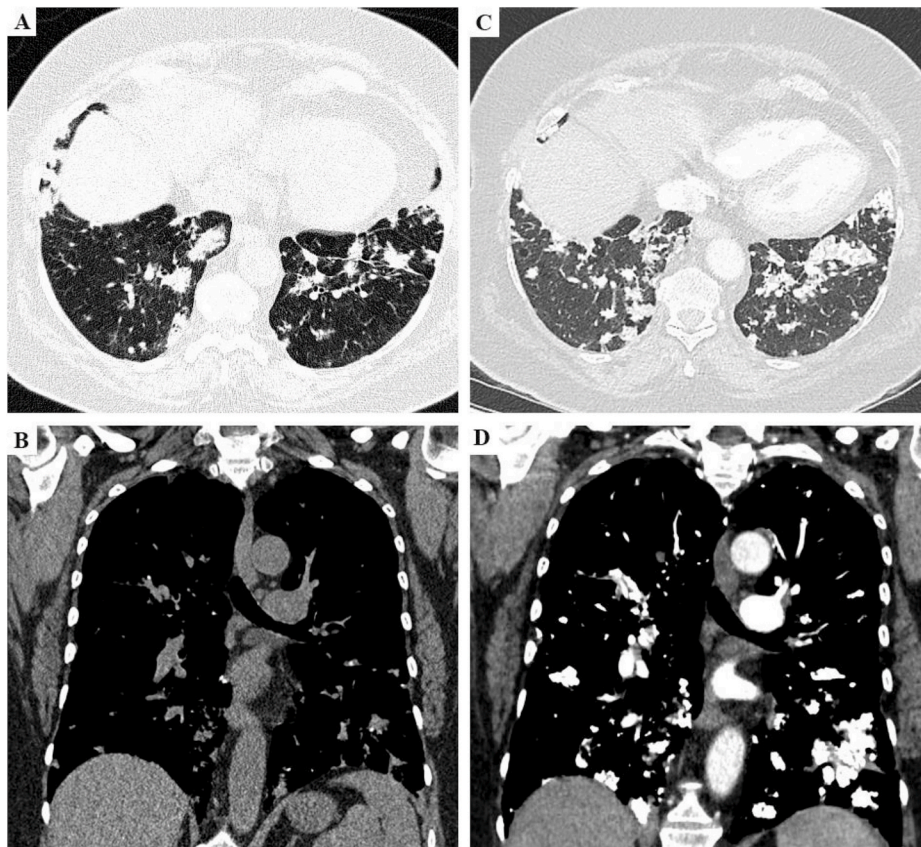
Computed tomography scans showed bilateral diffuse nodules and areas of parenchymal consolidations (A,B). Follow-up computed tomography scan after 10 years observation showed progression and evolvement of the bilateral multiple consolidations and nodules (C). Consolidations and nodules are calcified (D).
